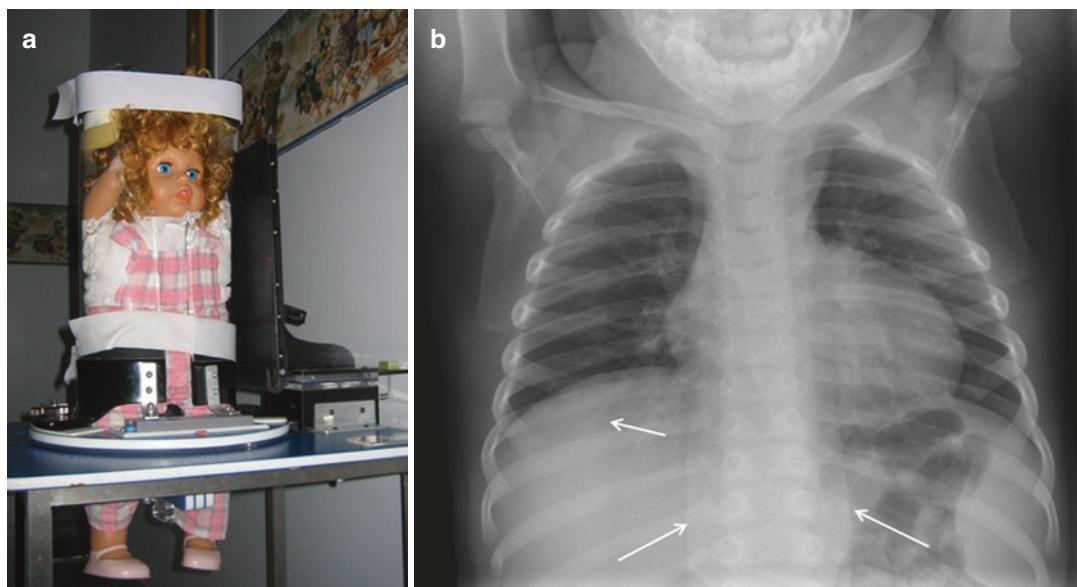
(a) “Pigg-O-Stat” device. (b) PA chest radiograph of a 2-year-old child obtained using the “Pigg-O-Stat,” showing commonly associated linear densities produced by the device (arrows)
